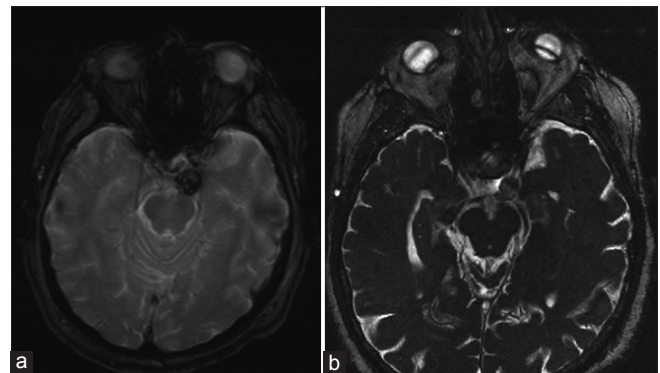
(a) Gradient echo MRI revealing round hypointense lesion with ferromagnetic susceptibility signals. (b) CISS MRI sequence revealing a left-sided heterogeneously enhancing lesion
